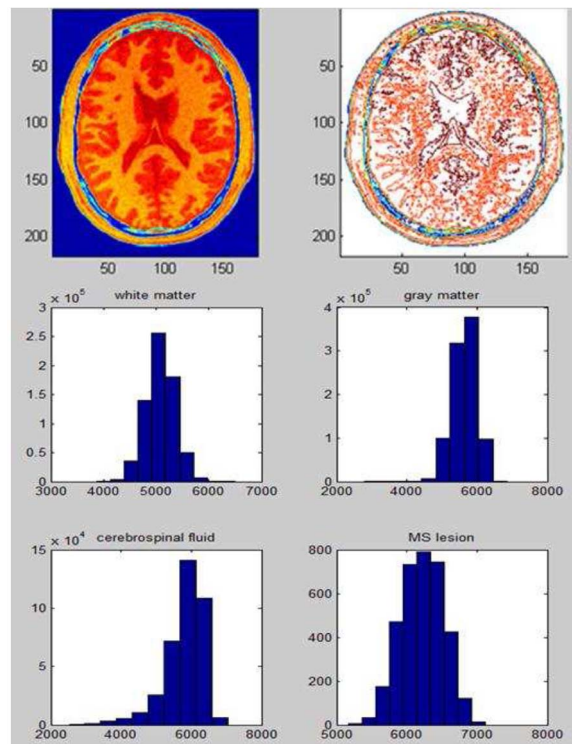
A PD-w MRI image with its contour plot and intensity histograms of WM, GM, CSF and MS lesions.
